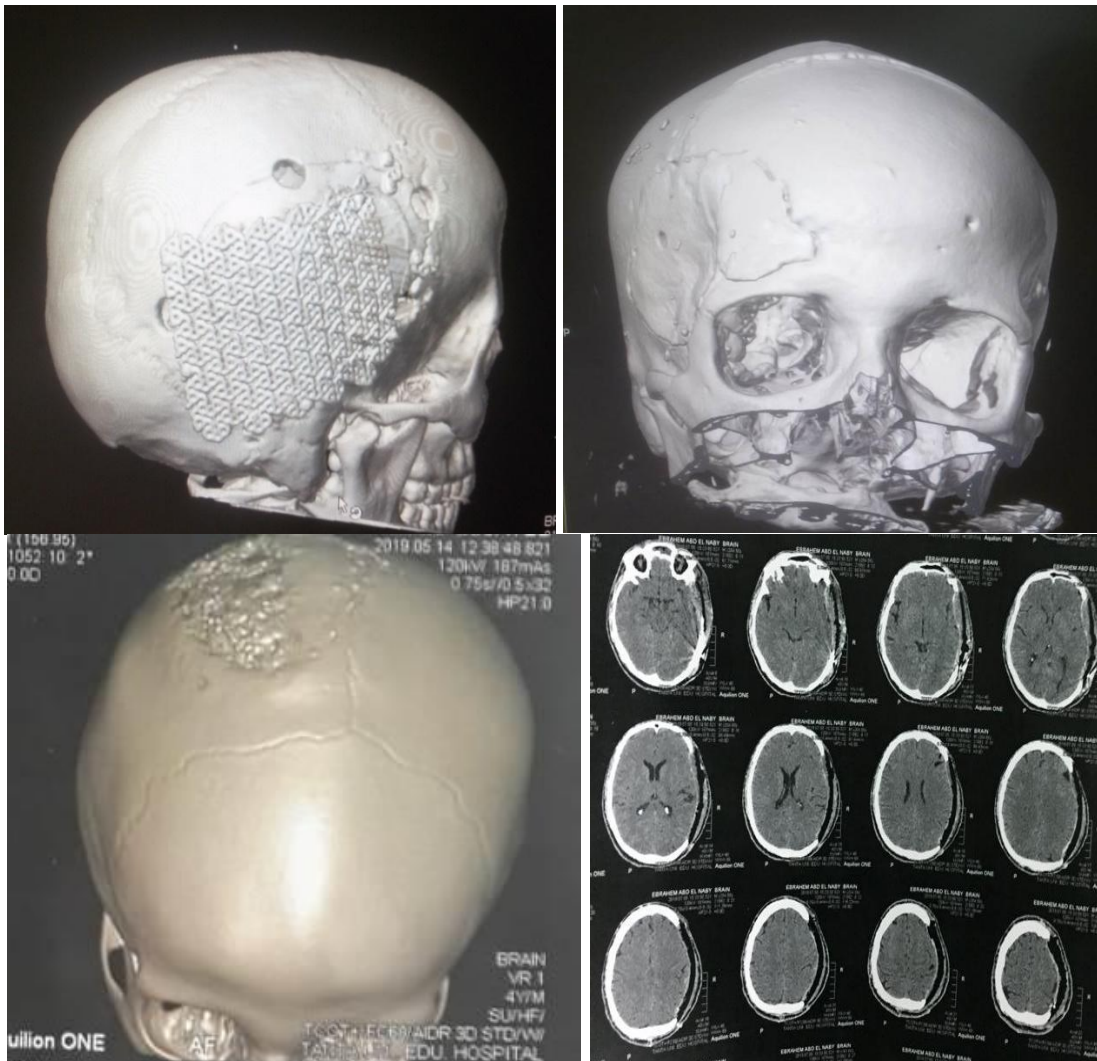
Follow up CT brain post-operative (A. Shows titanium mesh, B. Shows methyl-methacrylate, C. Shows hydroxyapatite, D. Shows 3D printed flap using poly-laurine-lactam)
